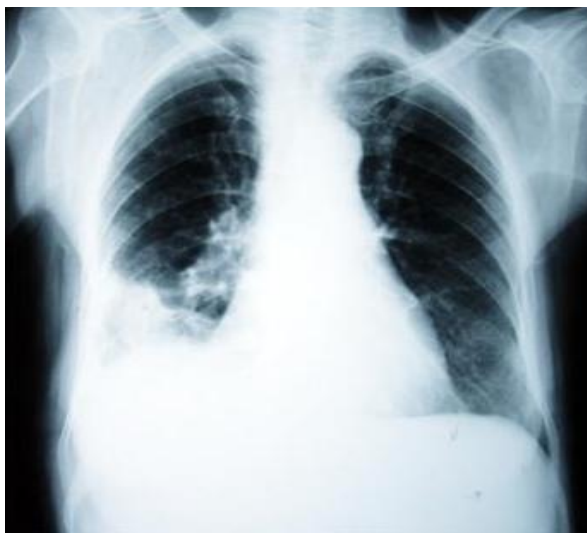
Chest radiograph showed right pleural effusion.
